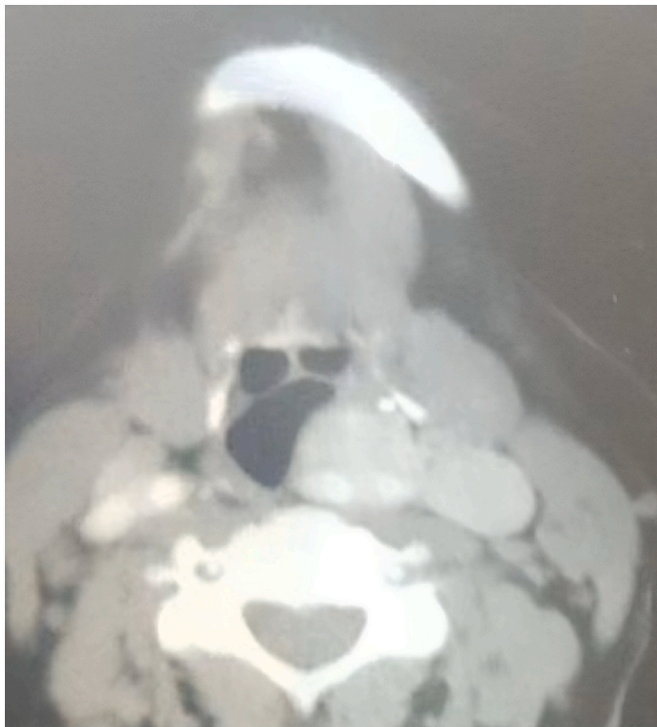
Computed tomography angiography (CTA) of the neck with contrast, axial section, shows an enhancing mass in the right side of the neck with mass effect on the right airway.
